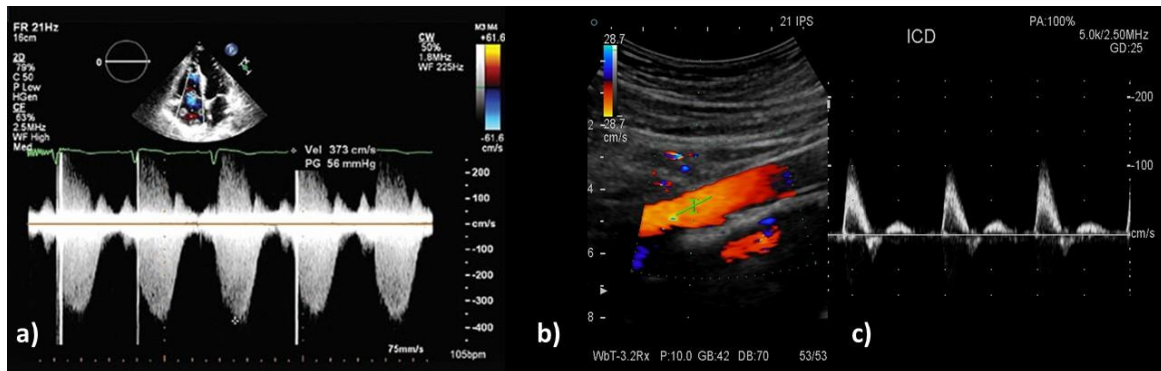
a) Continuous wave Doppler spectrum of the heart. A B-mode image is displayed on top of the spectrum to help the clinician positioning the Doppler line (dotted white) where the spectrum is computed. No information on depth is obtained and the velocities extracted correspond to the velocities alongside all the Doppler line.
